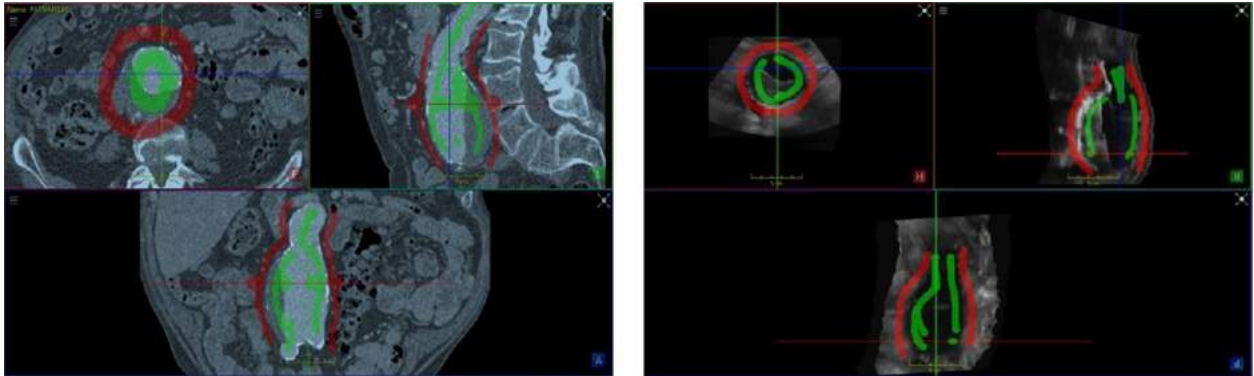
Shows the seeds defined by the user on the AAA wall: green (inside) and red (outside) for CT images (left) and 3D-US images (right)[151].
